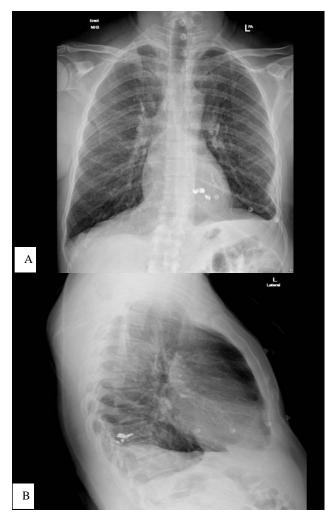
(A and B): Chest X-ray reveals a blunt left costophrenic angle accompanied by haziness in the left lower zone.
